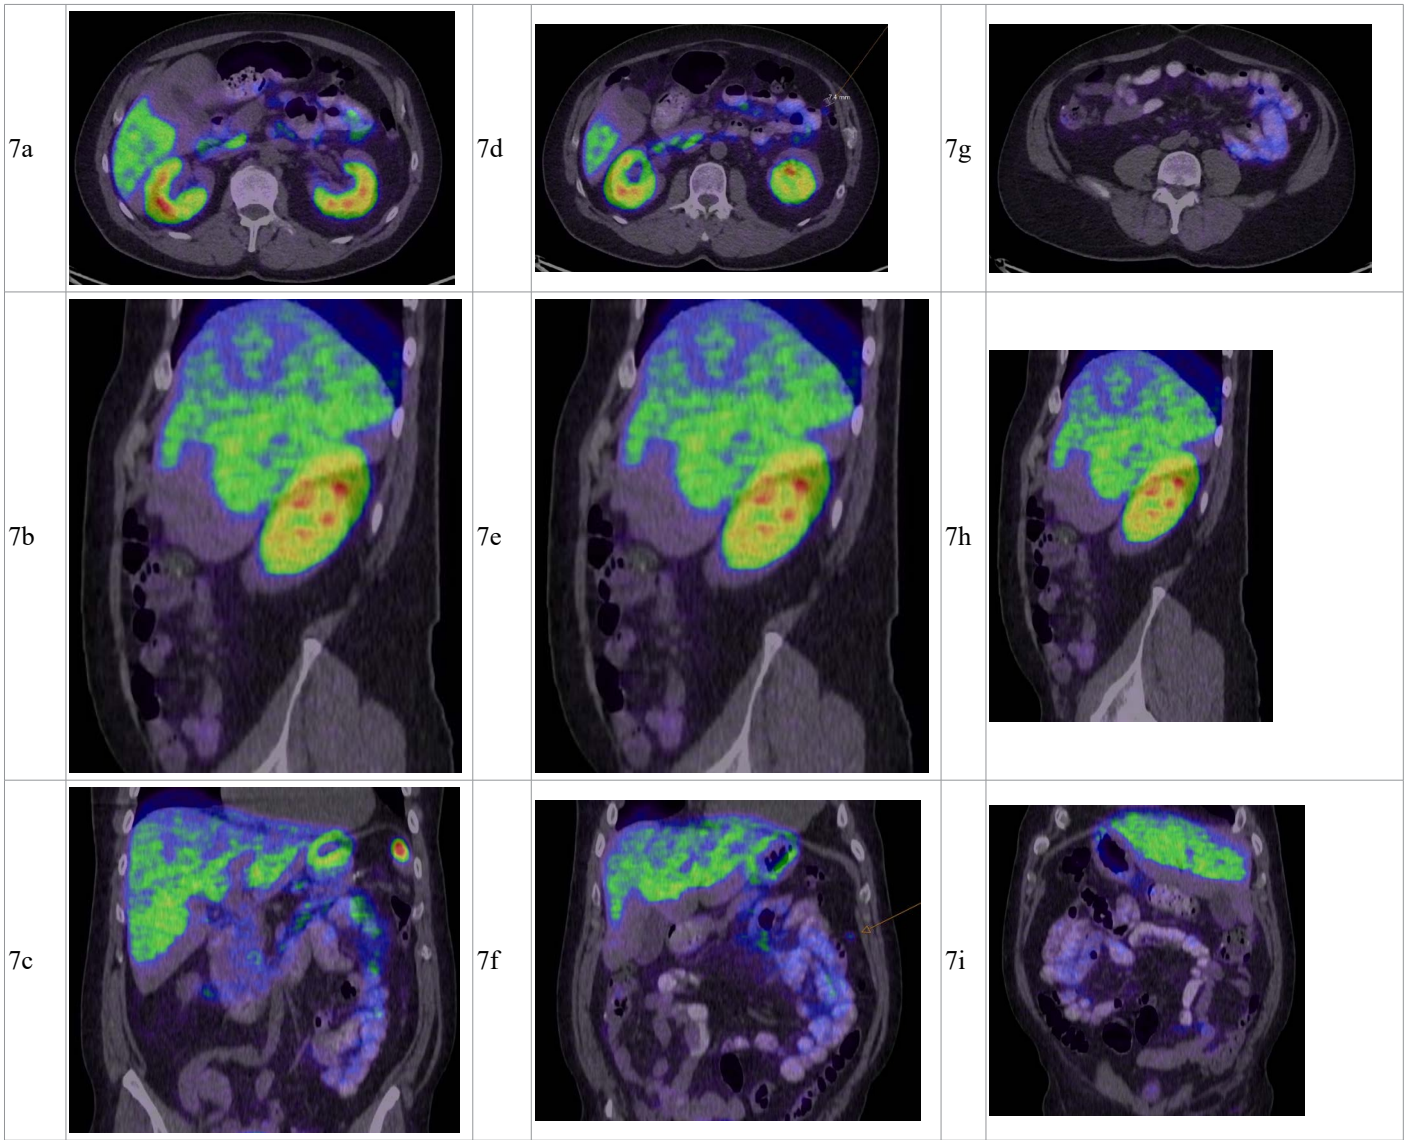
Follow-up Ga-68 DOTATATE PET/CT demonstrating persistent uptake within a peritoneal splenunculus with no evidence of recurrent neuroendocrine tumour.
